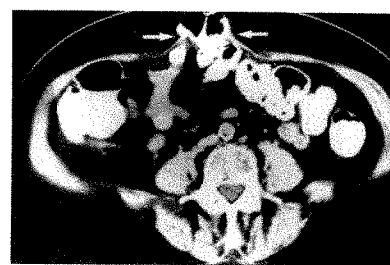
Paraumbilical hernia. CT scan shows midline abdominal wall defect in paraumbilical region with bowel (arrows) extending to skin.
